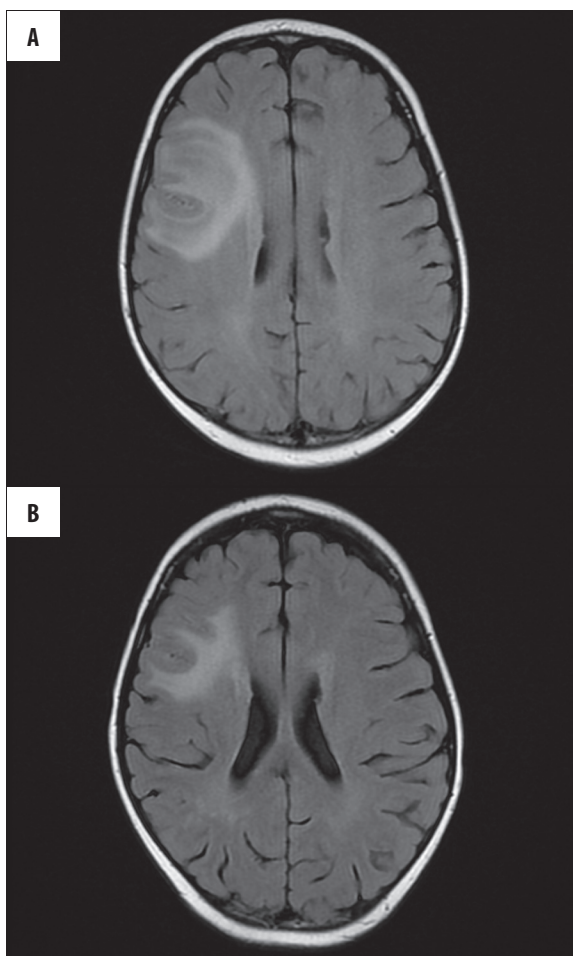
Boy BM, age 8. MRI examination during chemotherapy shows focal mycosis in right brain hemisphere. In check MRI partial remission.
